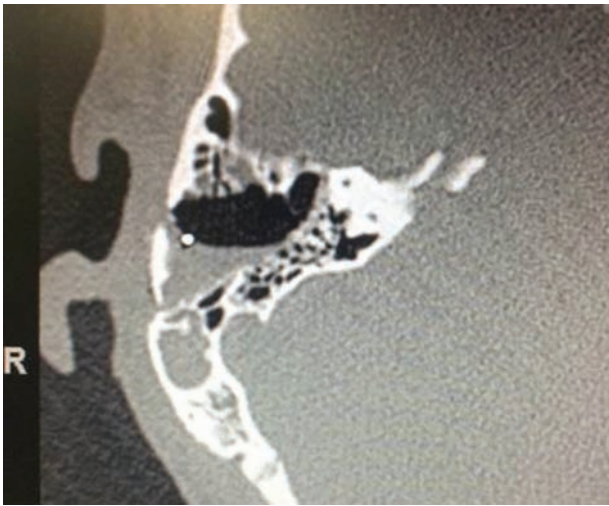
Bone axial computed tomographic image obtained immediately after surgery in a patient who underwent cochlear implant surgery with a flap.
